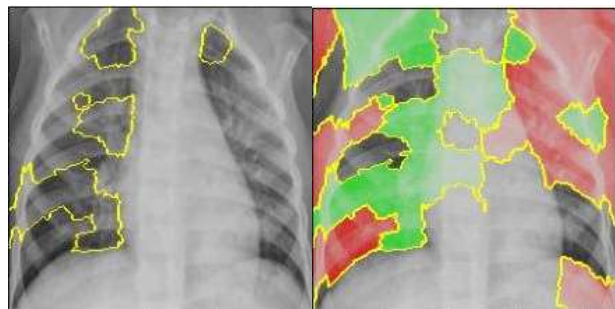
Chest X-Ray of a person with pneumonia. Left: yellow boundary indicates the top 5 features that cause the trained EfficientNet model to classify the image as “Pneumonia”. Right: green and red regions indicate features that contributed positively (and negatively, respectively) towards “pneumonia” classification
